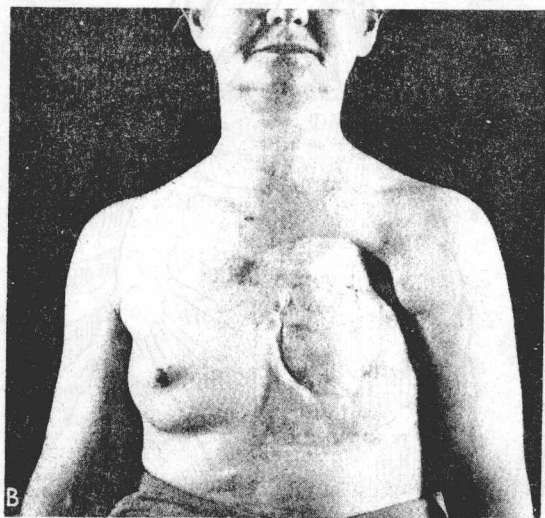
A, Forced inspiration depends on the "bucket-handle" motion of the ribs and the "pump-handle" motion of the sternum. This energy-consuming effort is mediated through the accessory muscles of respiration and occurs when metabolic demand outstrips ventilatory capabilities at rest. Excessive removal of the chest wall in the wrong patient can activate this response and lead to exhaustion. B, The accessory muscles of inspiration include the sternocleidomastoids, the scalene muscles, the external intercostals, and the parasternal intercartilaginous muscles. These activate the bucket-handle and pump-handle mechanisms. (From Seyfer, A., Graeber, G., and Wind, G. (Eds.): *Atlas of Chest Wall Reconstruction*. Rockville, MD, Aspen Publications, 1986, p. 28.)
